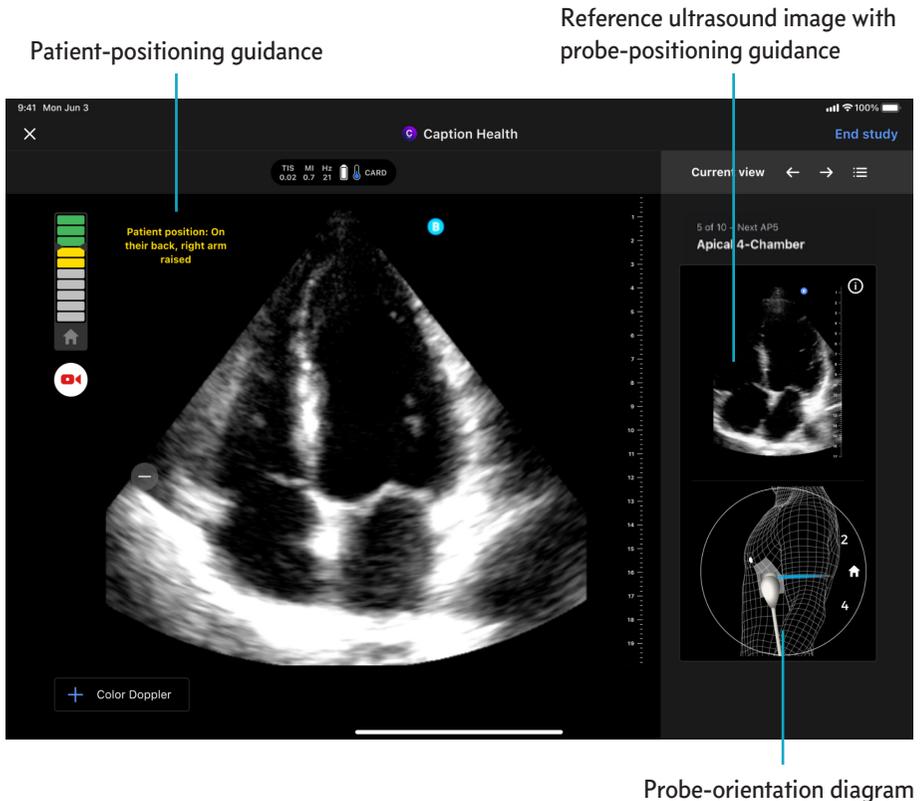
Ultrasound display: features for setting up to scan
